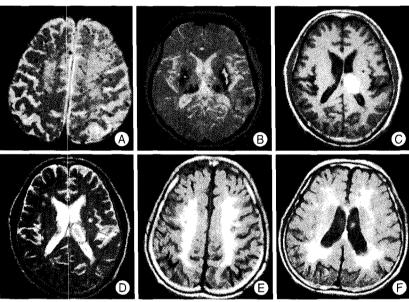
Definitions and classifications of magnetic resonsance (MR) imgaing abnormalities in different patients of spontaneous intracerebral hemorrhages (ICHs). A numerous small round hypointense lesions, silent microbleeds, are detected by gradient-echo (GRE) sequence on the both cerebral hemispheres (A). Two old hematomas from prior ICHs, fluid-filled cavities with black rim, are clearly revealed in the both basal ganglia with GRE MRI (B). Lacuna shows the hypointensity on T1-weighted MR and the hyperintensity on T2-weighted MR imaging in this case of left thalamus hematoma (C and D). Advanced white matter hyperintensity (grade 3) and periventricular hyperintensity (grade 3) are shown on the fluid attenuated inversion recovery MR images (E and F).
